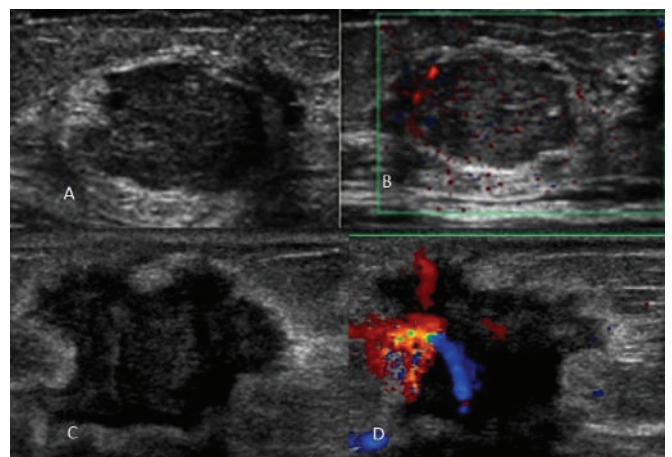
Image A shows an ultrasound image of a benign nodule (fibroadenoma) showing smooth margins while Image B is a color Doppler image of the same lesion showing a lack of blood vessels. Image C is an ultrasound image of an invasive ductal cancer demonstrating irregular margins with abundant blood flow shown on the color Doppler image (D).
